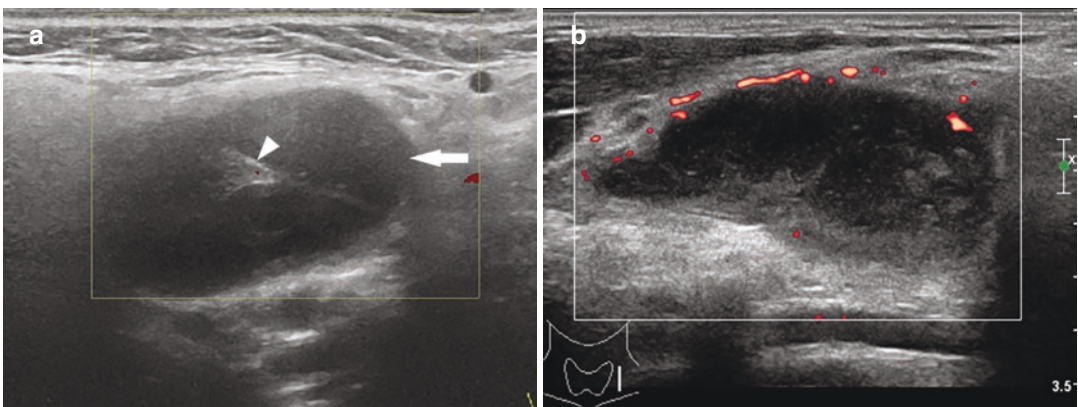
Color Doppler US imaging of tuberculous lymphadenitis in two different patients. (a) Early change in tuberculous lymphadenitis. The lymph node is enlarged with hypoechoic cortex thickening and decreased vascular flow (arrow). The hilar fat is effaced (arrowhead). (b)
